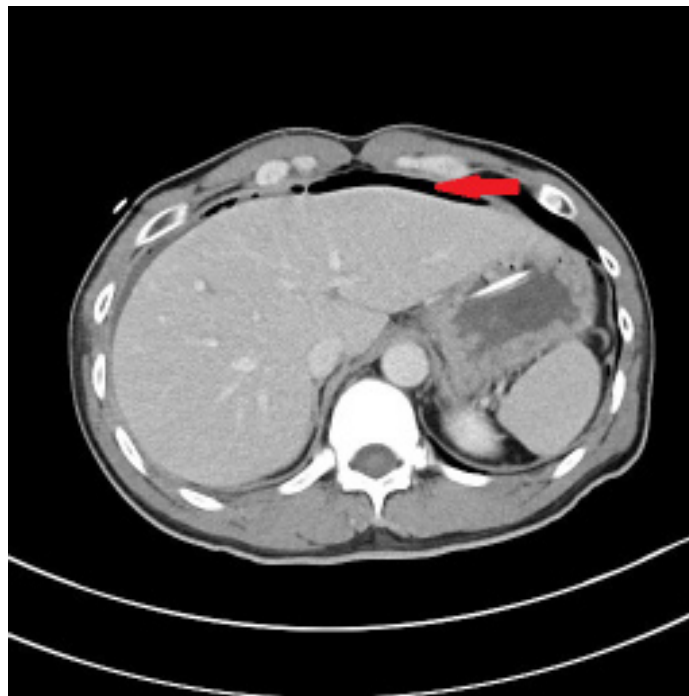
Abdominal contrast CT, showing pneumoperitoneum anterior to the left lobe of liver and in the epigastrium.
